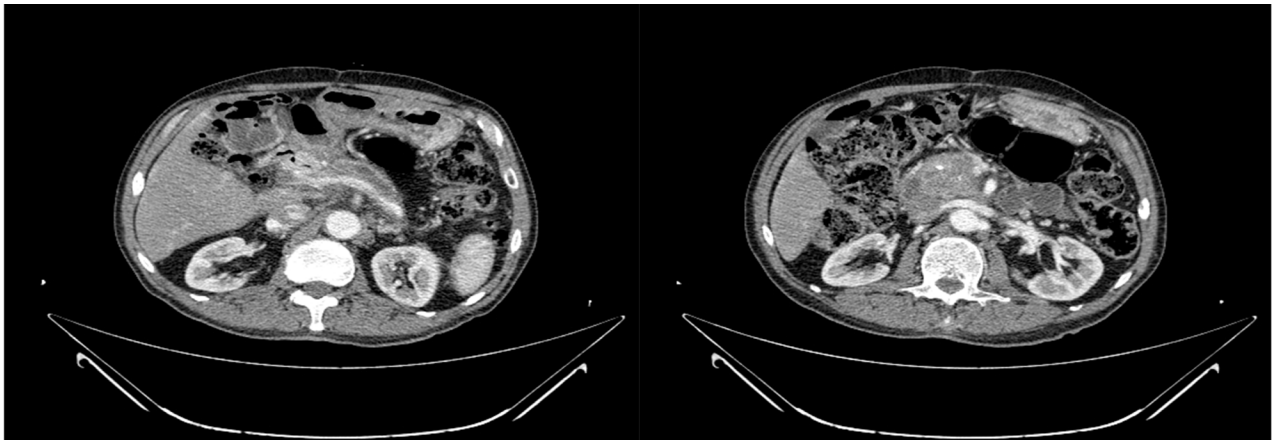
A computed tomography (CT) scan that showed a volumetric reduction of the pancreatic head with splenic vein recanalization.
